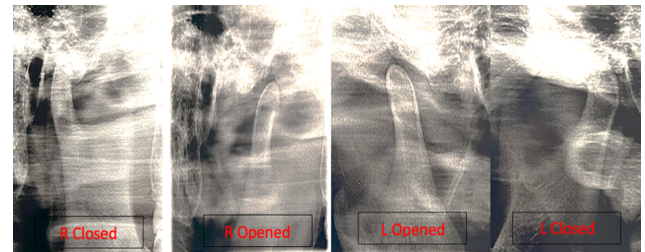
TMJ radiography image
